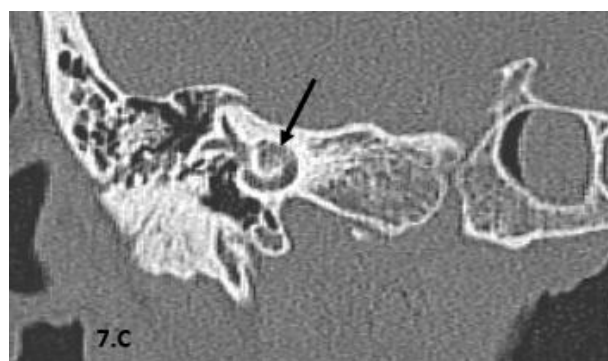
C: right coronal oblique CT view, bone window revealed normal vestibule and normal SCCs morphology (black arrow).
